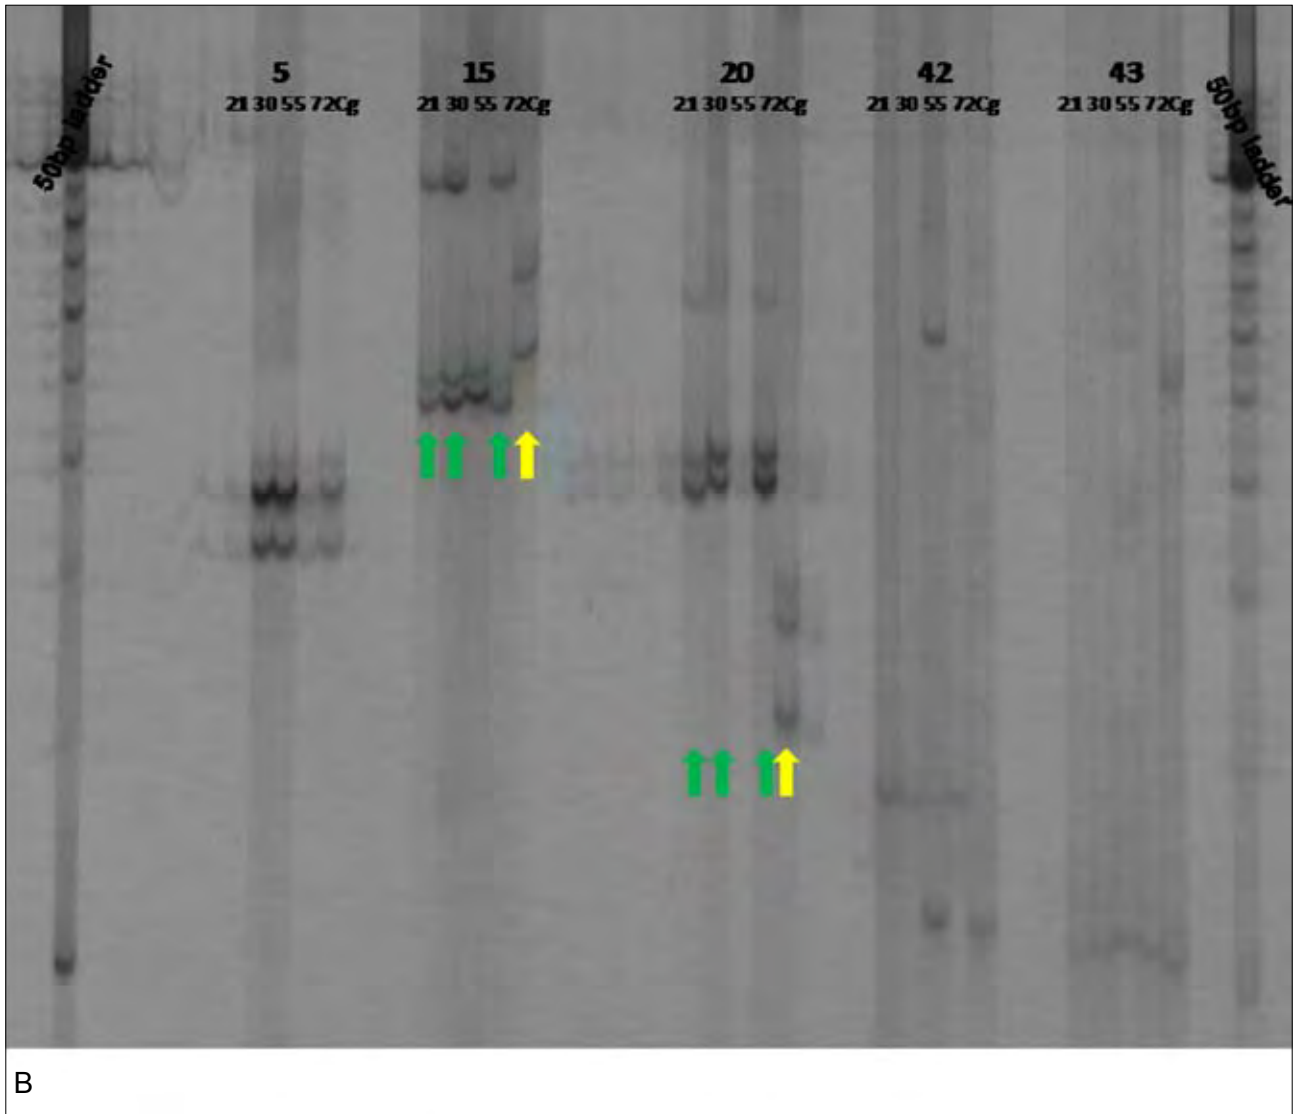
Varied Resolutions of EST-based markers on SSCP Gels. A. Gel indicating polymorphisms between CT-55 (Soybean) and CT Lentil isolates. B. Gel indicating polymorphisms between *Colletotrichum graminicola* (Wheat) and CT Lentil isolates.
